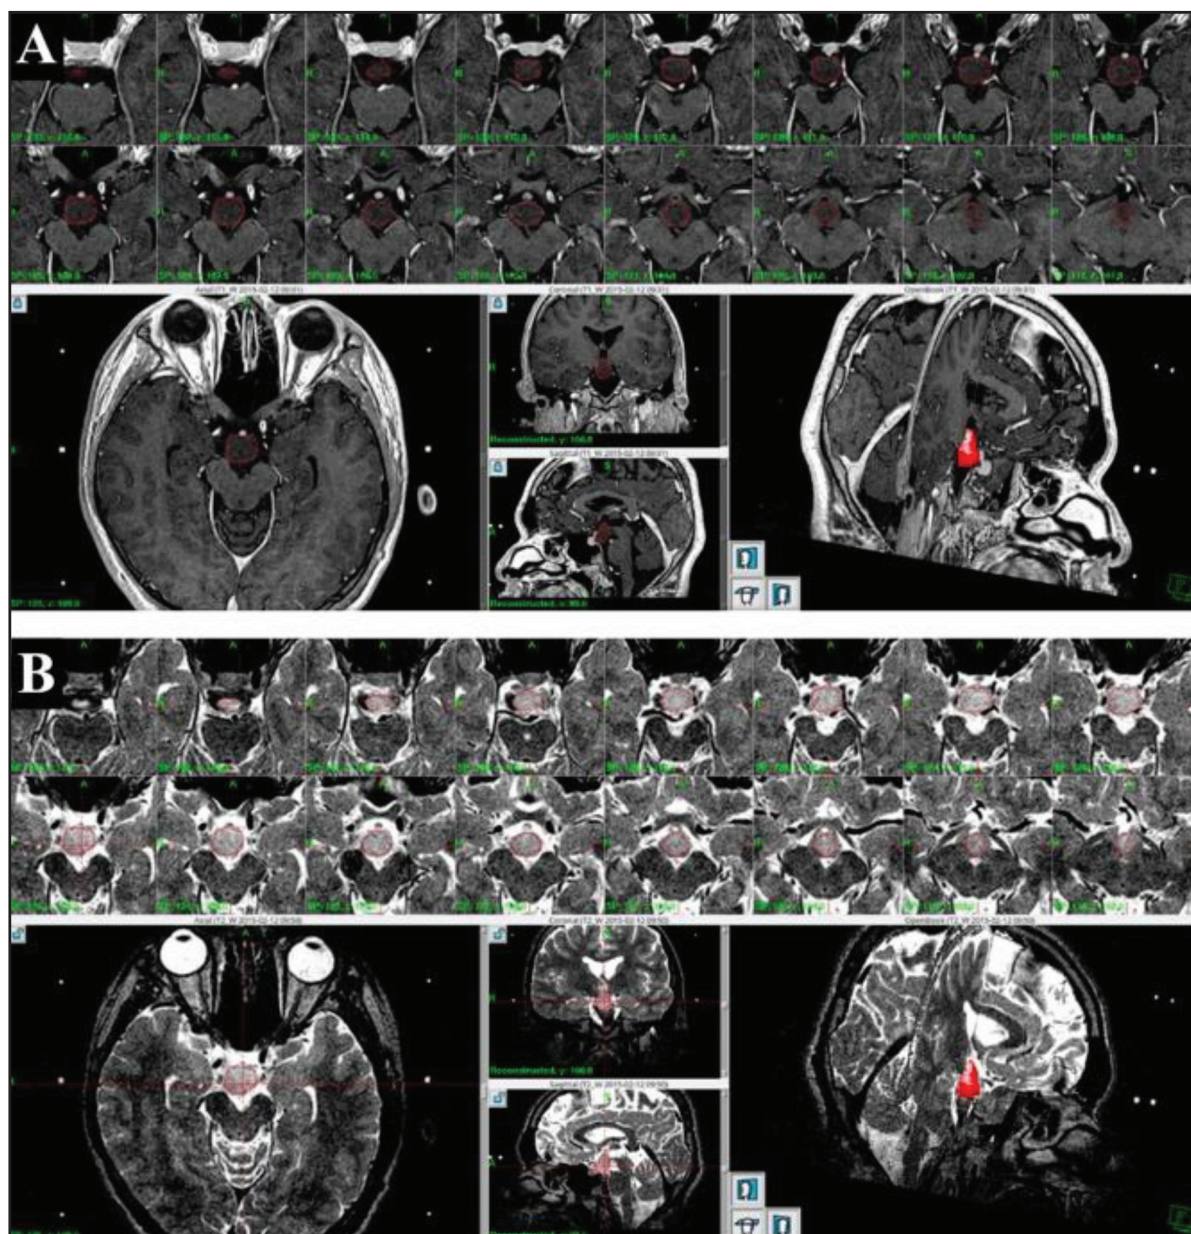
Pre-treatment MRI of Case 1. Axial T1-weighted (A) and T2-weighted (B) images demonstrating a non-enhancing retrochiasmatic HH (Delalande type III) located in the suprasellar region. The lesion measured 2.100 cm³ and was selected as the target for GKRS.
